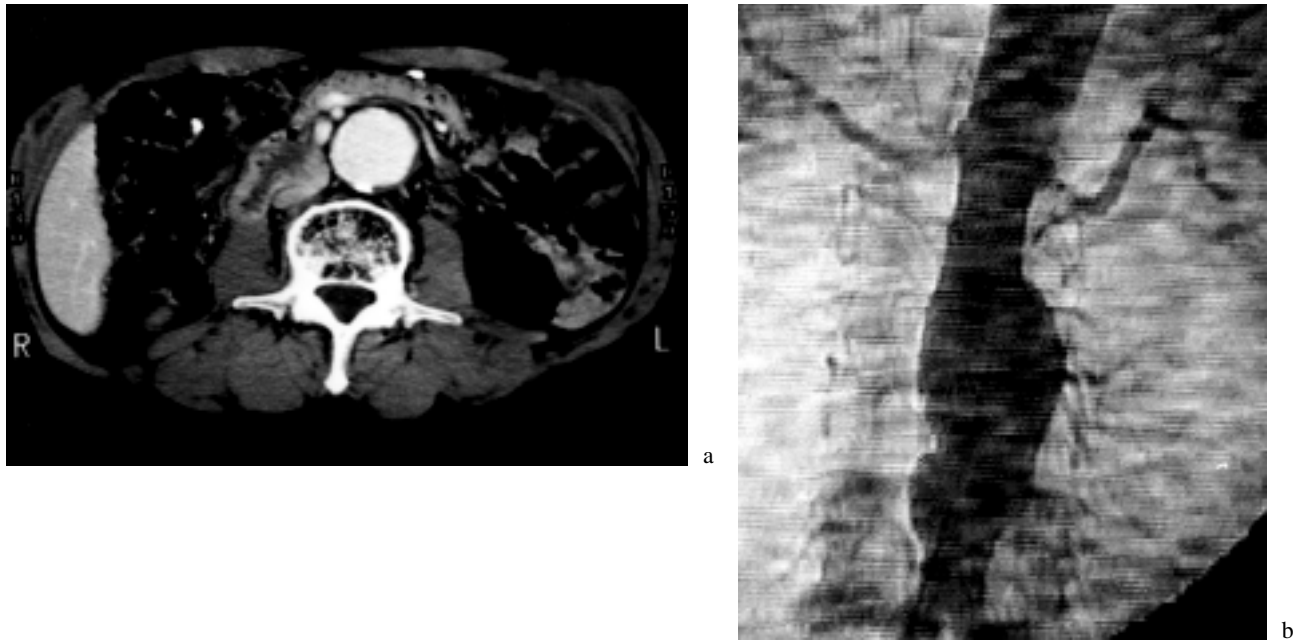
Angiogram (a) and computed tomography (CT) (b) in case 2. Angiogram reveals a 90% stenosis of the left renal artery.
